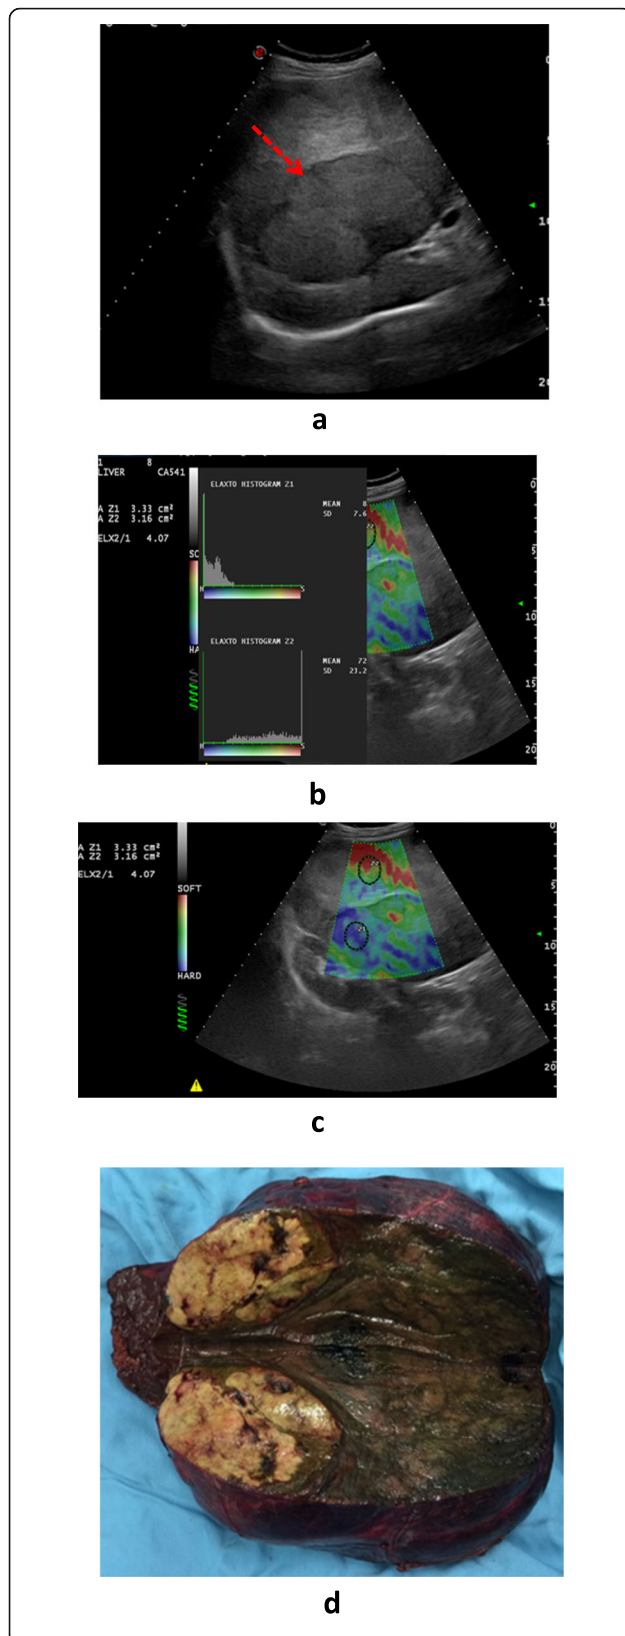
A 48-year-old male patient with a well-defined FHL as determined by ultrasound (a) with a strain ratio of 4.9 as shown by ultrasound elastography (b), the histogram of the lesion (c) and the pathological finding of cholangiocarcinoma
